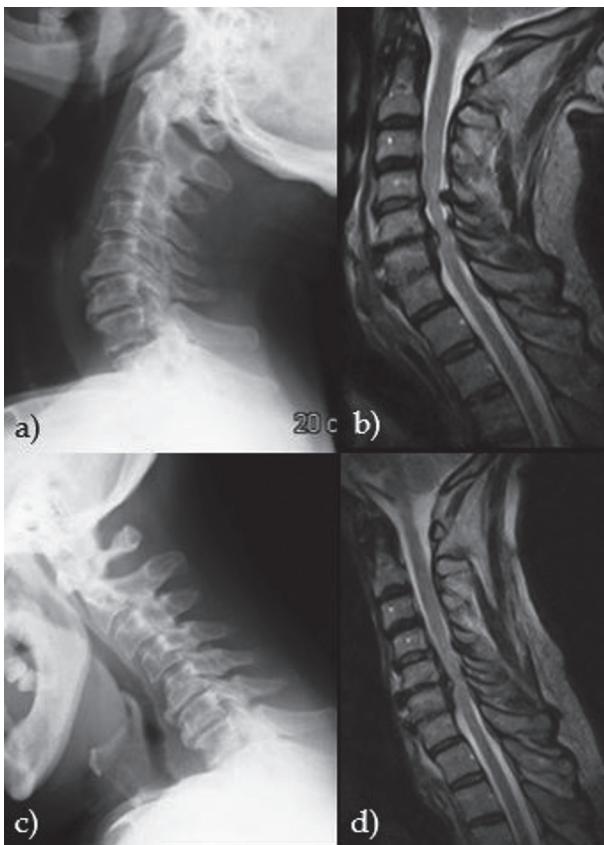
Cervical Spine MRI in extended (a, b) and flexed (c, d) position. The extended position better underlines both cervical disc bulges and the yellow ligament hypertrophy with its extrusion (unmatched aspect in the flexed position)
